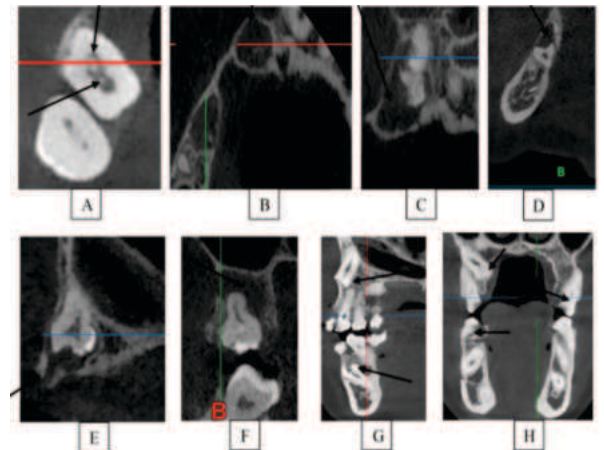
CBCT sections (coronal, transaxial, axial and sagittal) shows AI (A, G and H), RO (B, C, E and F), DD (D).
